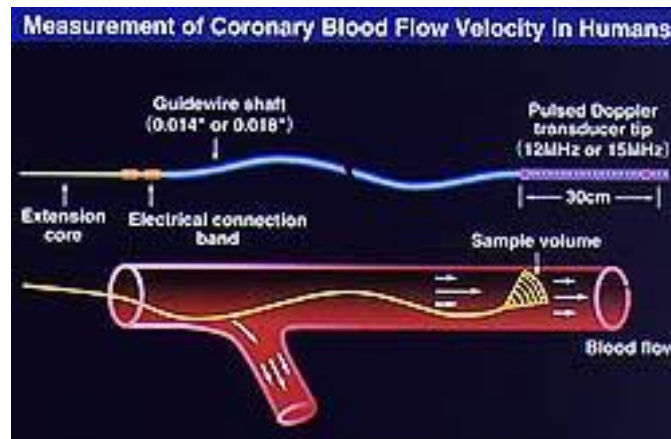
Endothelial dysfunction assessment via a Doppler wire
